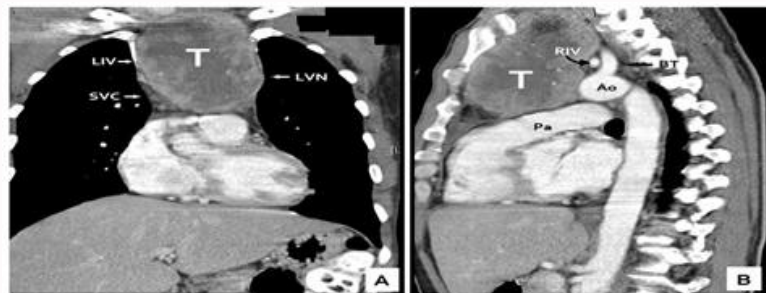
Coronal and sagittal images of contrast-enhanced chest computed tomography showing the anatomic relationship between sarcoma (T) and the surrounding neurovascular structures: aorta (Ao), brachiocephalic trunk (BT), Left and Right Innominate Veins (LIV, RIV), Main Pulmonary Artery (Pa), Superior Vena Cava (SVC) and Left Vagus Nerve (LVN).
